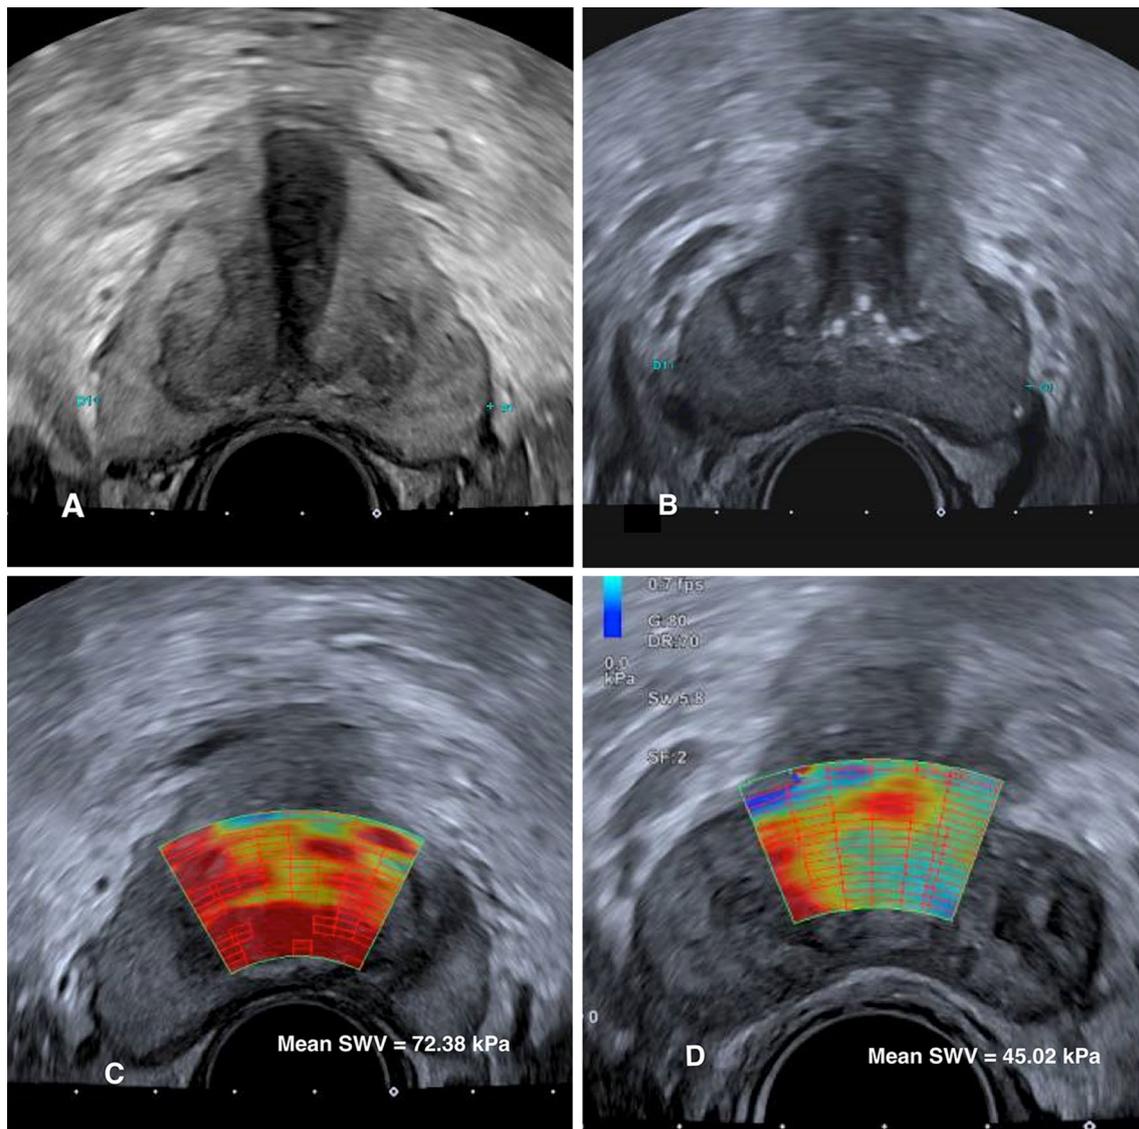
Pre-PAE (A) and 1-month follow-up (B) transrectal ultrasound showing volumetric reduction of the gland, notably of the transitional zone. (C, D) Ultrasound Elastography demonstrating reduction of prostatic elastic modulus after PAE
